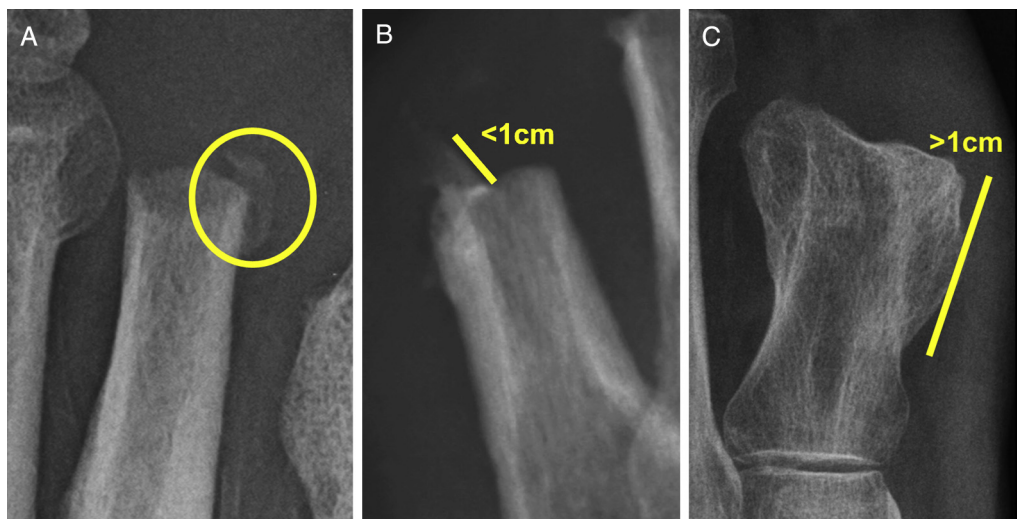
Radiographic examples of successive heterotopic ossification (HO) stages. (A) HO is believed to originate in the soft tissues adjacent to bone (31), which is characterized as grade I HO. (B) Grade II HO exhibits bone formation less than 1 cm in length. (C) Grade III HO is much more expansive, measuring greater than 1 cm in length. The distinction of “a” or “b” after the grade indicates HO without or with an associated ulcer, respectively.
